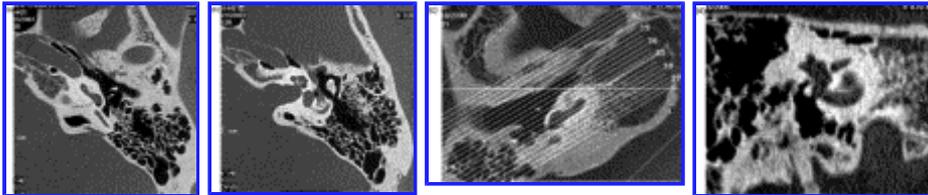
Unenhanced HR spiral CT, contiguous native sections of 0.5-mm thickness, axial plane, bone windows settings evaluate cochlear structures: (a) below, sausage-shape of the basal turn with parallel side walls and osseous lamina inside. Air filling the round window niche under the subiculum. (b) Apical and mesial cochlear turns communicating with the IAM by the modiolus. Well-pneumatized mastoid cells. (c) Reconstructed section, 'Stenvers plane', parallel sections to the petrous bone. (d) Cochlea and basal turn.
